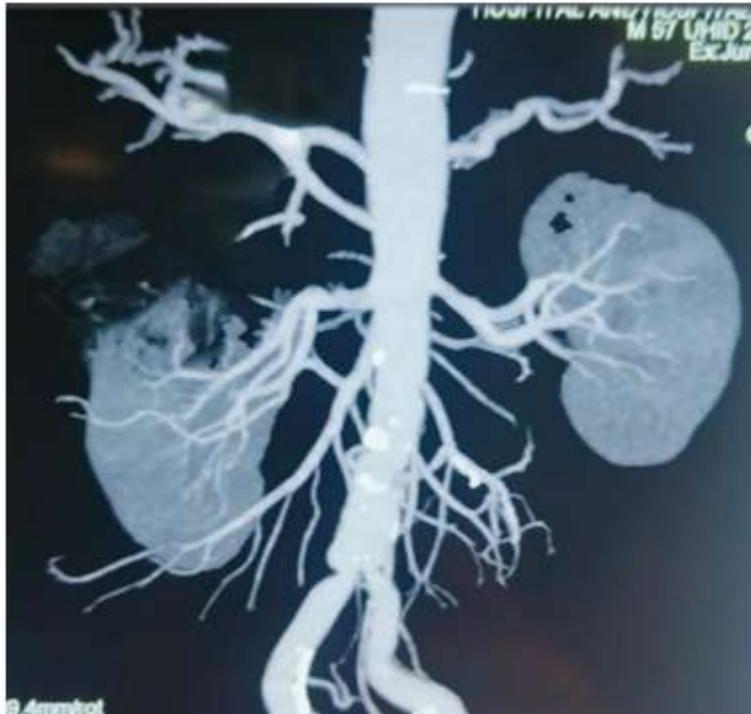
CT angiography showing Replaced PHA from SMA and GDA from Celiac trunk
